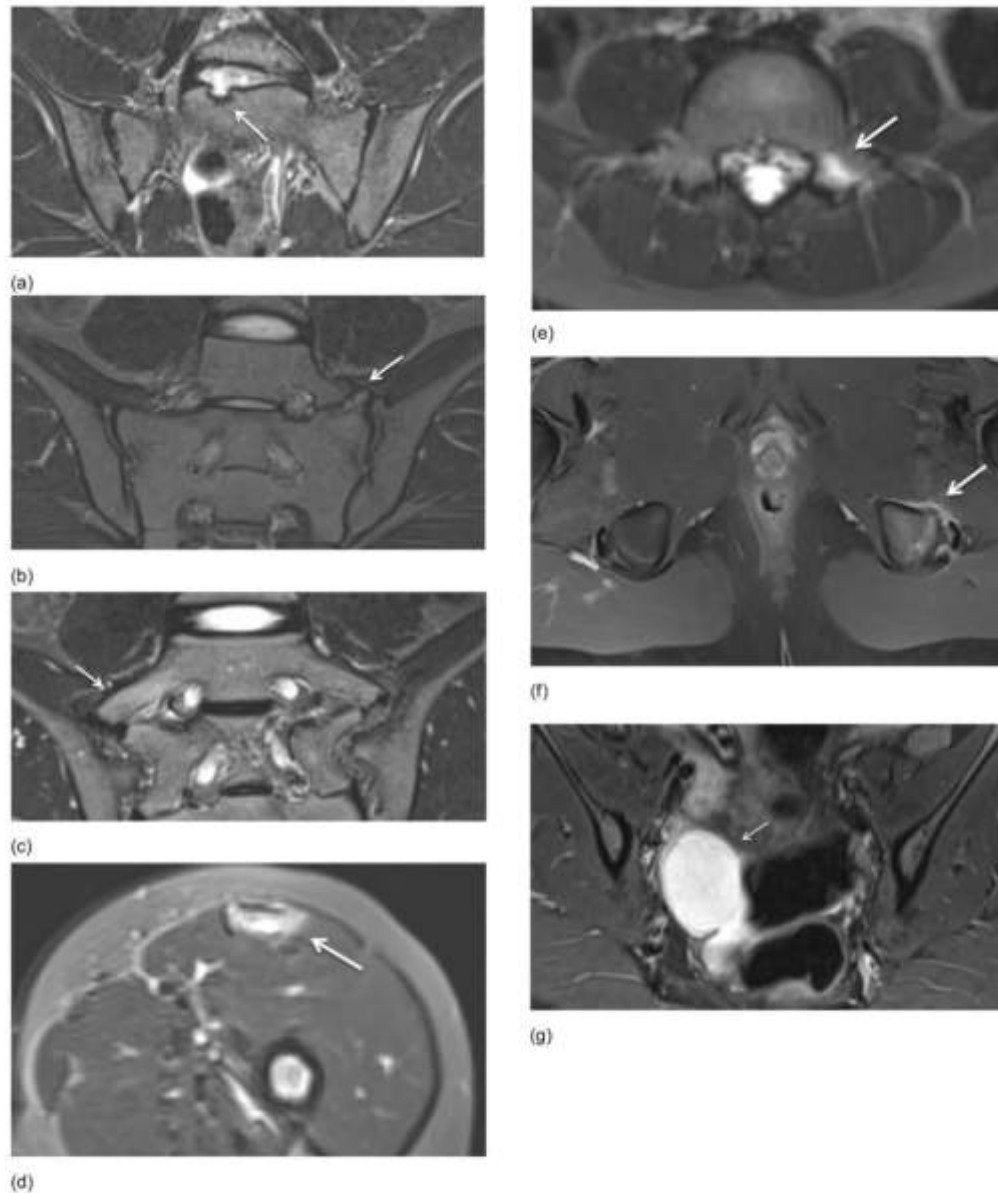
Incidental findings seen on MRI of SI joints in different patients. (a) Semicoronal STIR MR image of a Schmorl's nodules (arrow) in a 12-year-old boy. (b) Semicoronal STIR MR image of a lumbosacral transitional variant on the left side without BME (arrow) in a 15-year old girl. (c) Semicoronal STIR MR image of a lumbosacral transitional variant on the right side with discrete BME (arrow) in a 13-year-old. (d) Axial STIR MR image of a muscle tear with hyperintense signal changes of the rectus femoris muscle (arrow) seen on the most inferior image in a 9-year-old boy. (e) Axial STIR MR image shows bone marrow edema of the pedicle on the left side (arrow) suspicious for spondylolysis in a 7-year-old boy. (f) Axial fat saturated T1-weighted MR image after IV Gd of an bony apophyseal avulsion with soft tissue edema and enhancement on the left side (arrow) in a 14-year-old boy. (g) Semicoronal STIR MR image shows an ovarian cyst (arrow) in a 14-year-old girl.
